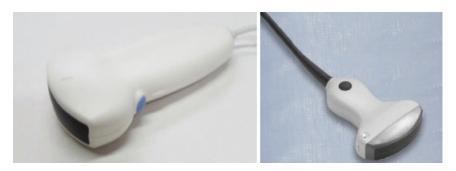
Transperineal convex ultrasound transducer
